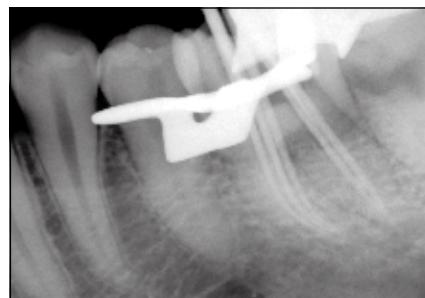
Radiograph taken to confirm master cone selection.
